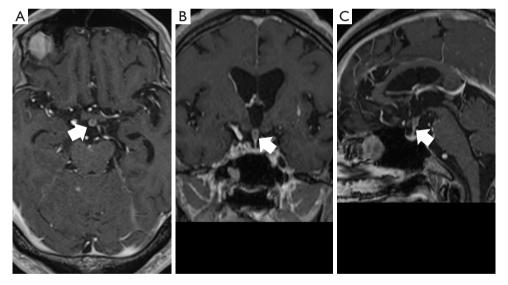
In special cases, contrast lesions indicating meningitis may also be seen around the pituitary stalk. (A) Axial, (B) coronal, and (C) sagittal images of the pituitary gland on postcontrast MRI demonstrate thickened enhancement (arrows) in the pituitary stalk. MRI, magnetic resonance imaging.
